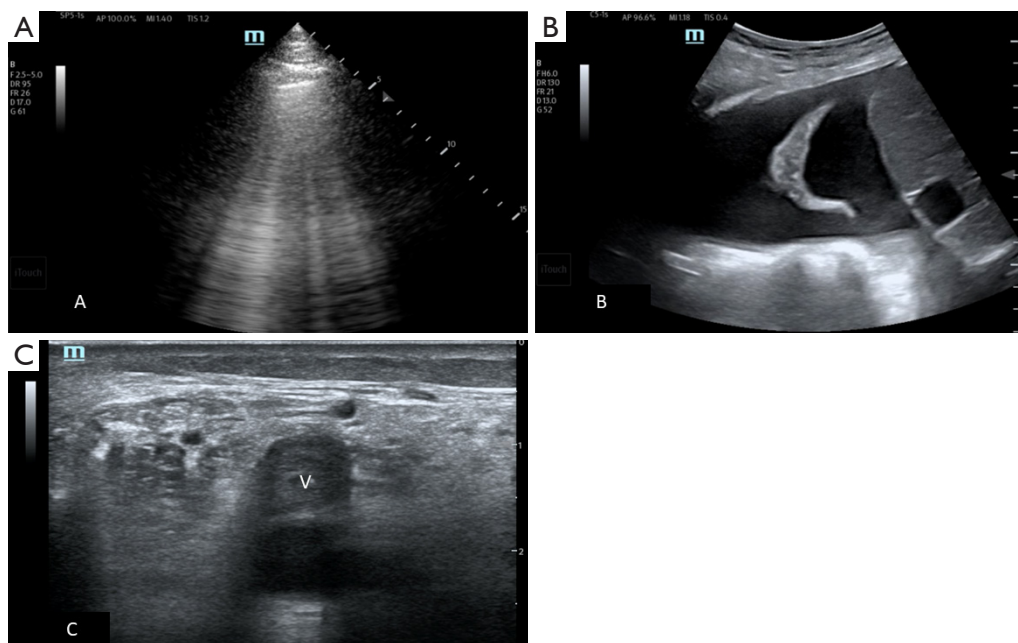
Sonographic examples. “M” denotes probe orientation marker. (A) B-lines seen on lung ultrasound; (B) pleural effusion; (C) thrombus seen in popliteal vein (denoted as V).
